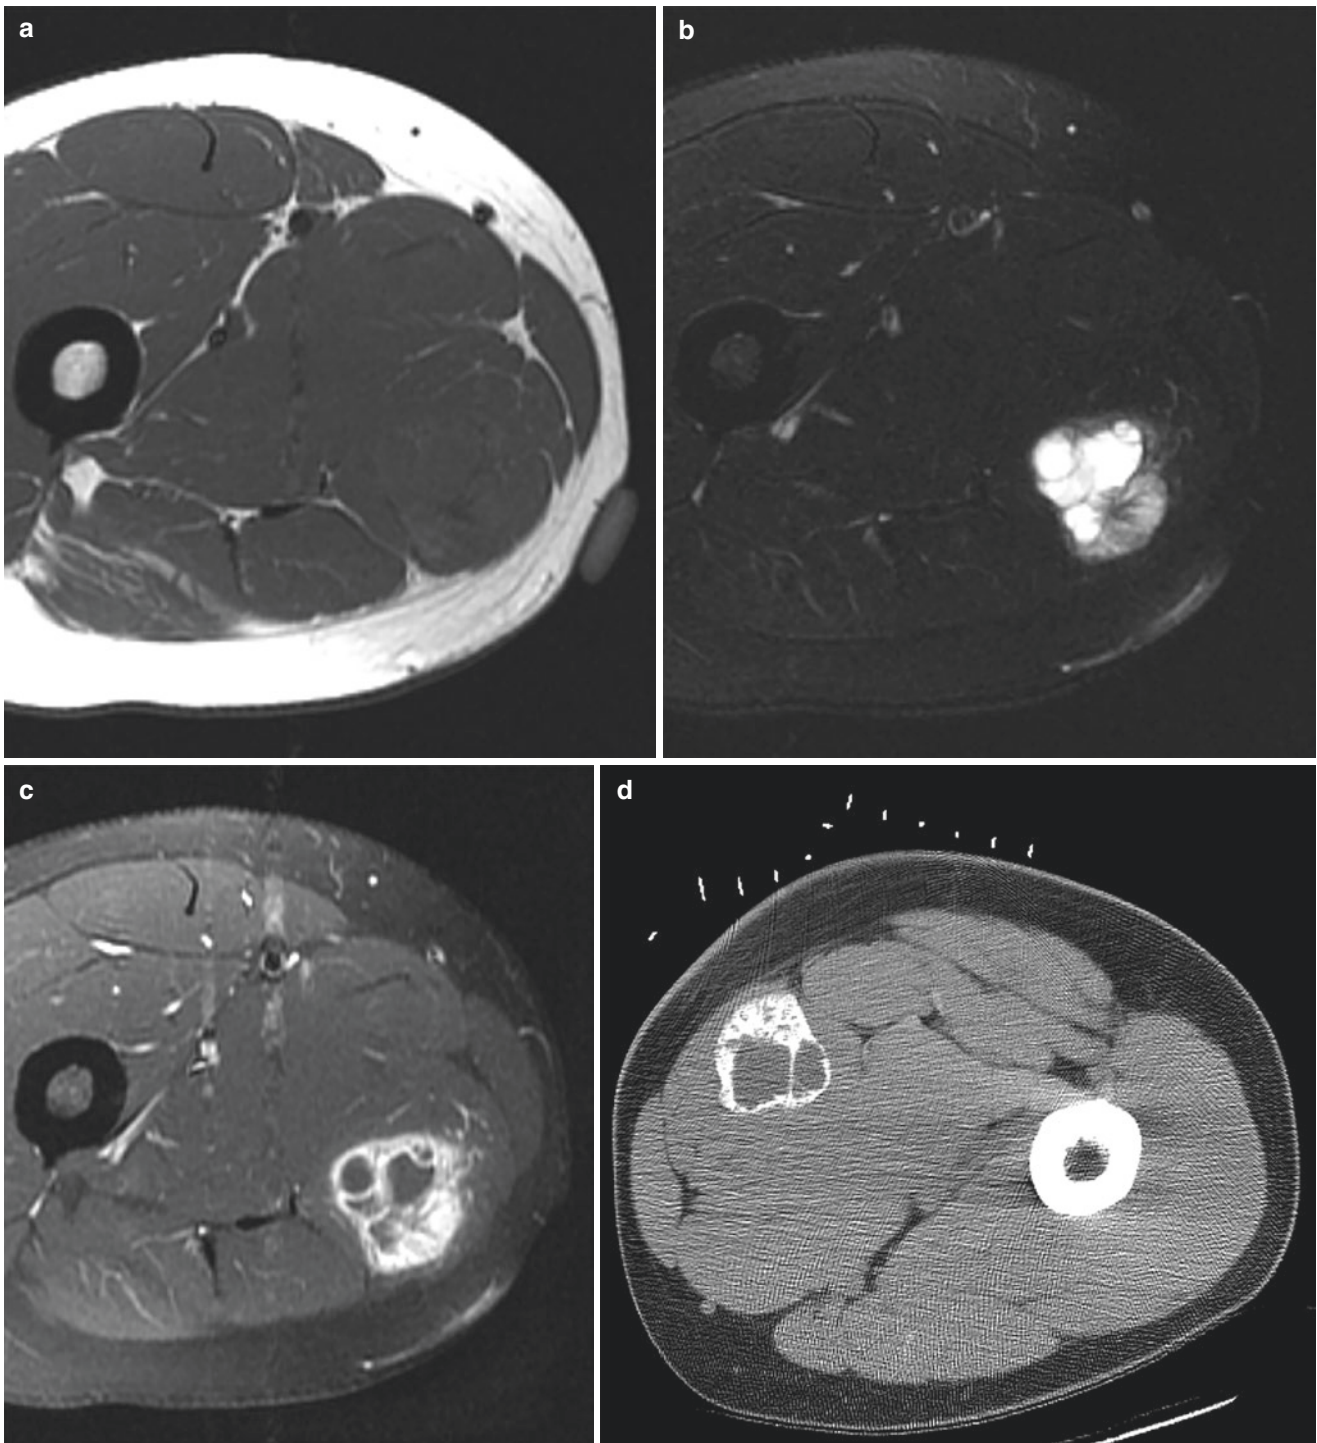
Myositis ossificans in a 31-year-old man presenting with a painful, palpable thigh mass. (a) T1-weighted axial image demonstrates skin marker and swelling of underlying adductor muscle. (b) T2-weighted, fat-suppressed axial image demonstrates a sharply demarcated mass with cystic and solid regions. (c) Following intravenous contrast administration, T1-weighted, fat-suppressed axial image demonstrates dense enhancement of periphery, septations, and solid
